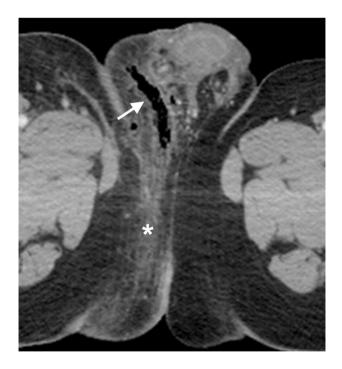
Typical findings of Fournier gangrene in CT. Axial enhanced CT image shows soft tissue edema and fascial thickening in the right perineum (*) and soft tissue gas in the right hemiscrotum (arrow)
